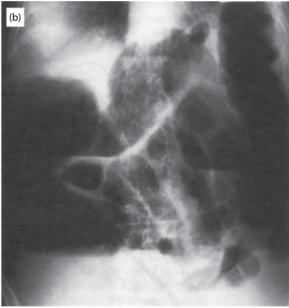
Plain abdominal radiographs showing large bowel obstruction: (a) supine film, (b) erect film, showing a fluid level in the caecum.
